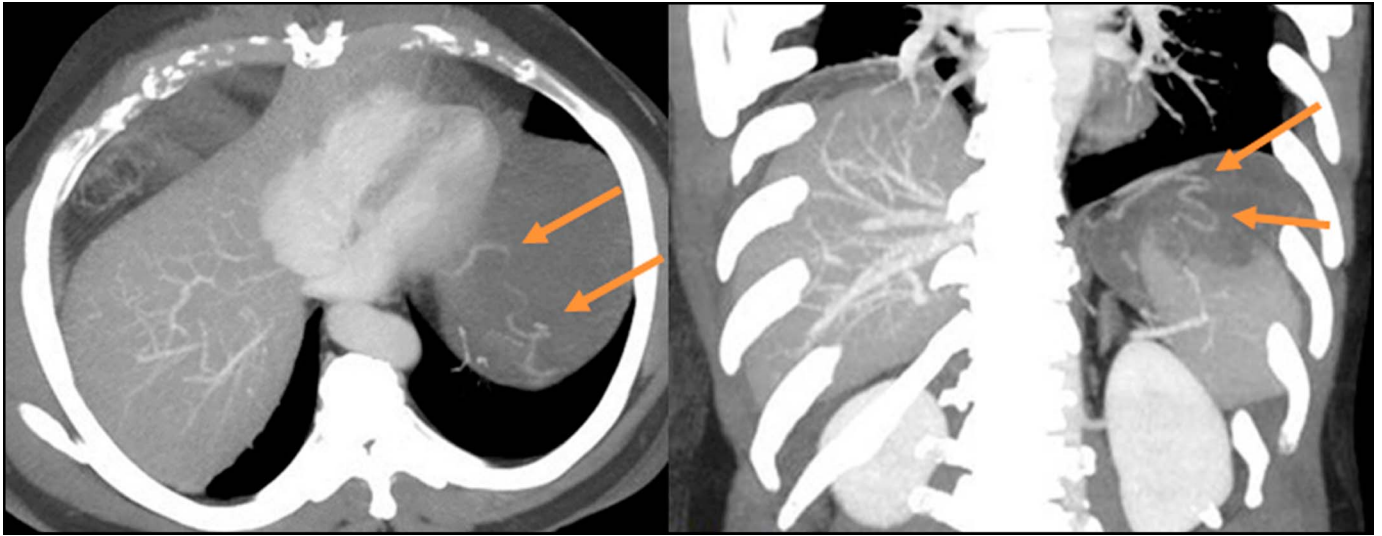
Axial (left) and coronal (right) abdominal computed tomography (CT) showing a prominent artery arising from the left phrenic artery and coursing through the gastric fundus (arrows).
